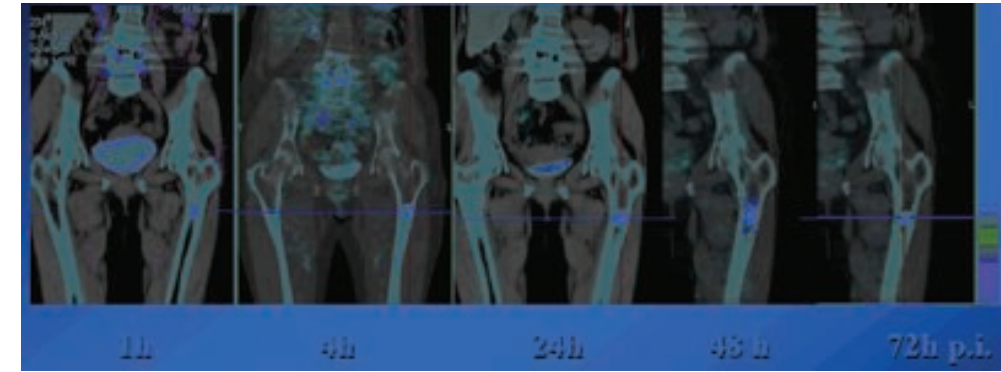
Co-registered PET/CT images over time in a patient
